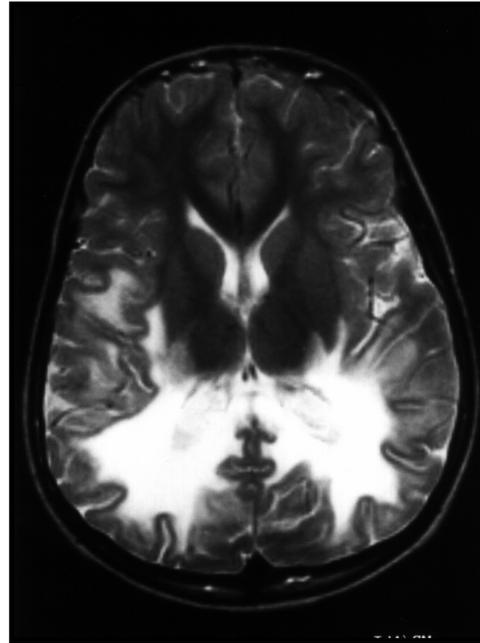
The MRI of the brain shows the characteristic low and high intensity signals of the abnormal parieto-occipital white matter on T2 weighted images.
